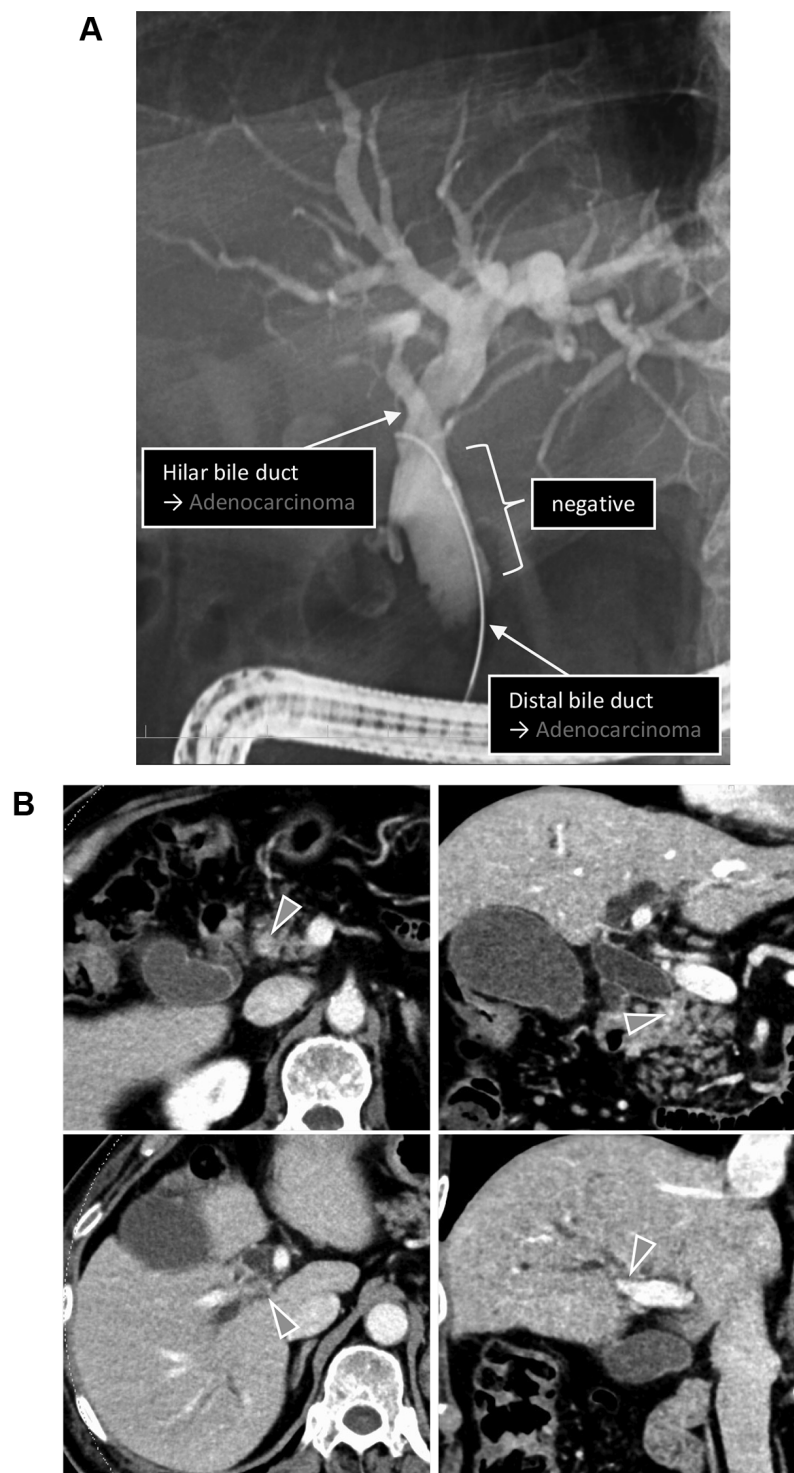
Preoperative endoscopic retrograde cholangiopancreatography image (A) shows adenocarcinoma in the hilar and distal bile ducts confirmed by biopsy. The arrows indicate the site of the biopsy in the bile duct. Contrast-enhanced computed tomography (B) shows solid mural thickening in the same regions. The arrowheads indicate the areas where findings suggestive of bile duct cancer are present.
